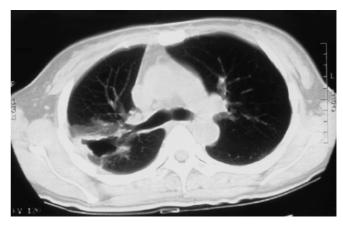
Computed tomography scan shows shrinkage of the fungal lesion
